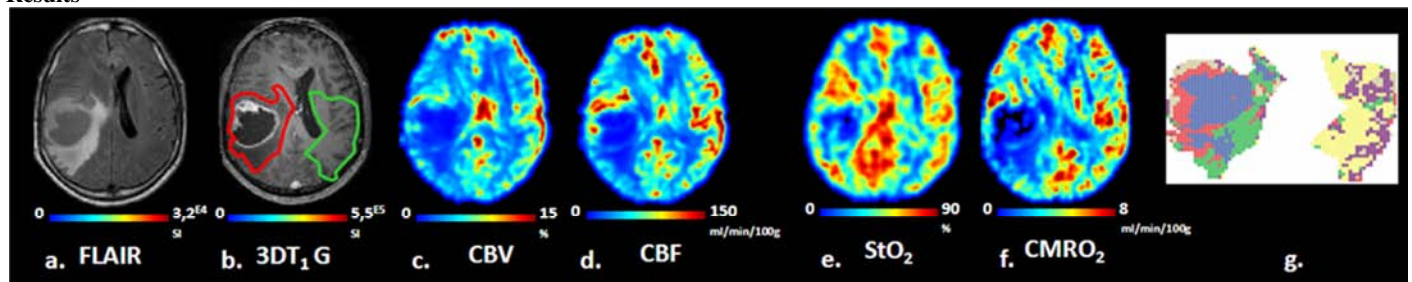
FLAIR (a), 3D T1 Gd (b). CBV (c), CBF (d), StO_2 (e) $CMRO_2$ maps (f) and model-based cluster analysis (g) from one patient with glioblastoma.
